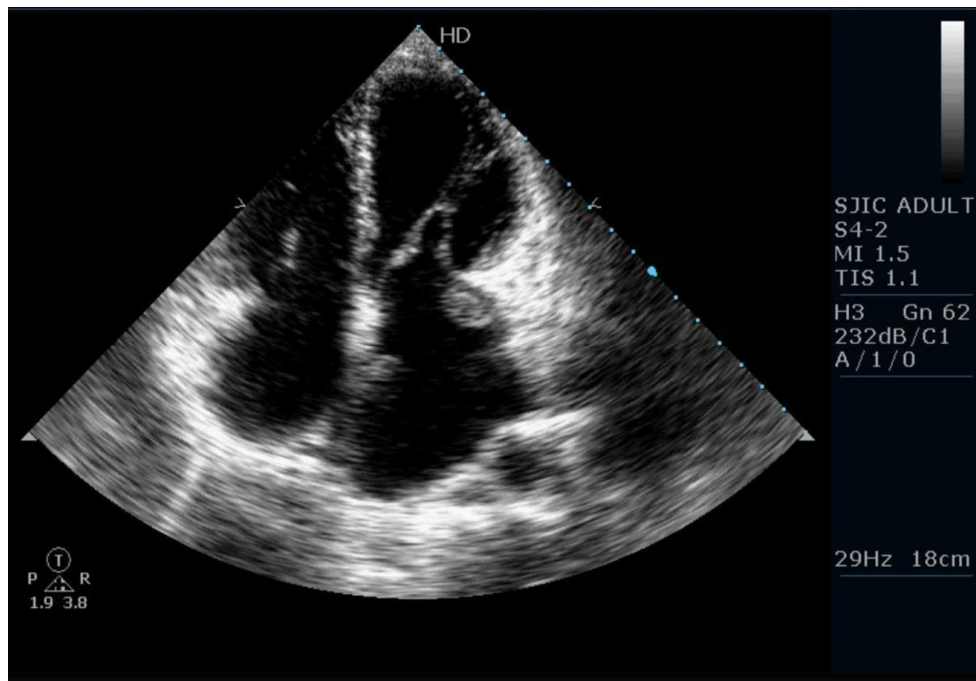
Apical four chamber view showing clots, one on interatrial septum towards LA and second near left atrial appendage
